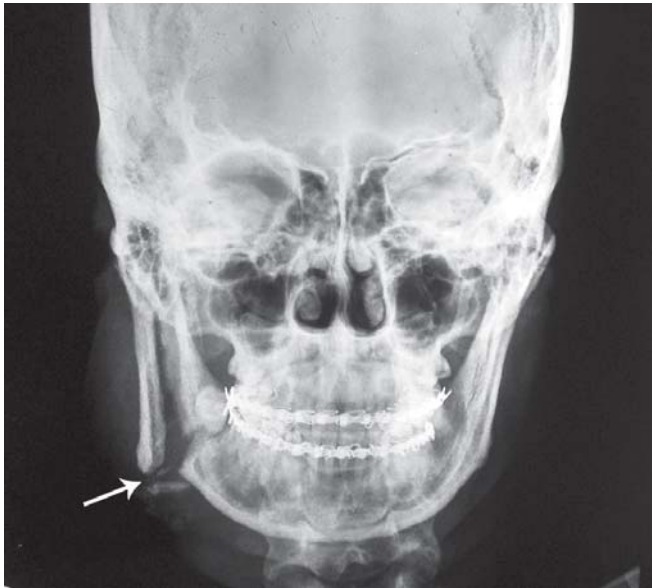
X-ray facial skeleton PA view showing fracture ramus and fracture angle of mandible on right side
